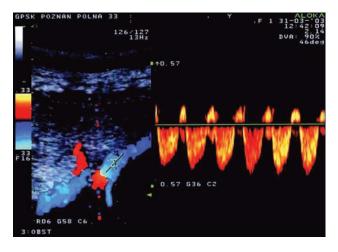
Color flow mapping of arterio–arterial (A–A) anastomosis in twin-to-twin transfusion syndrome (left), and (right) pulsed Doppler waveforms obtained from superficial A–A anastomosis indicating bidirectional blood flow
